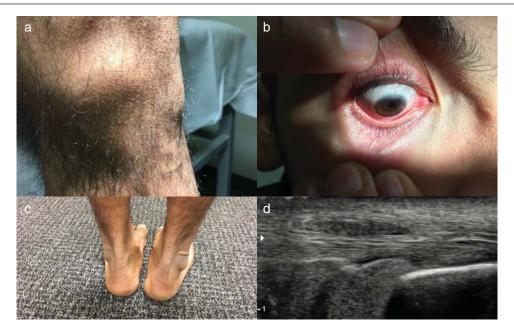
(a) Patella tendon xanthoma, (b) Arcus cornealis (arrow), (c) Achilles tendon thickened on physical examination, and (d) Achilles tendon xanthoma on ultrasound (arrow).
